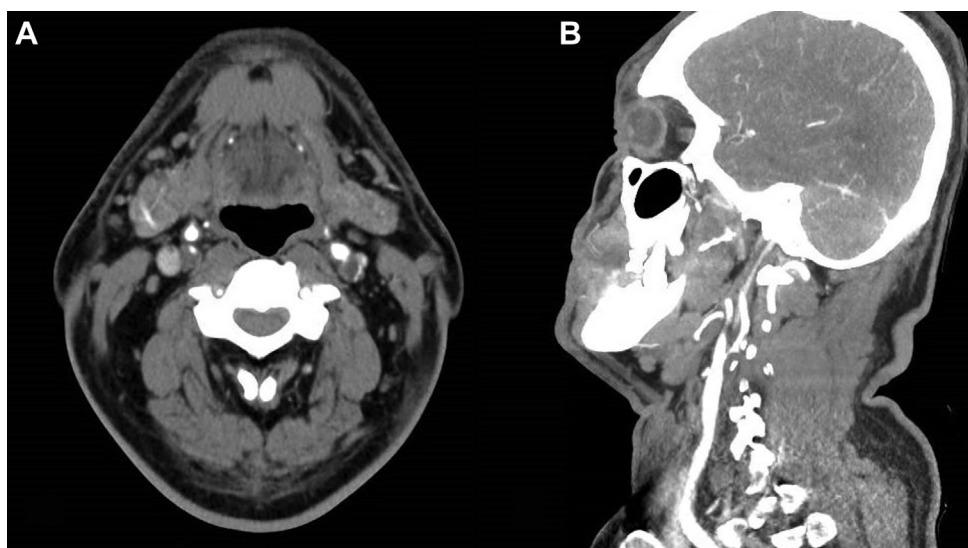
Computed tomography angiogram of the head and neck. Two images showing carotid stenosis. A, Axial slice of a computed tomography angiogram of the neck. It shows bilateral high-grade carotid stenosis. B, Sagittal slice of the same study showing left carotid stenosis.
